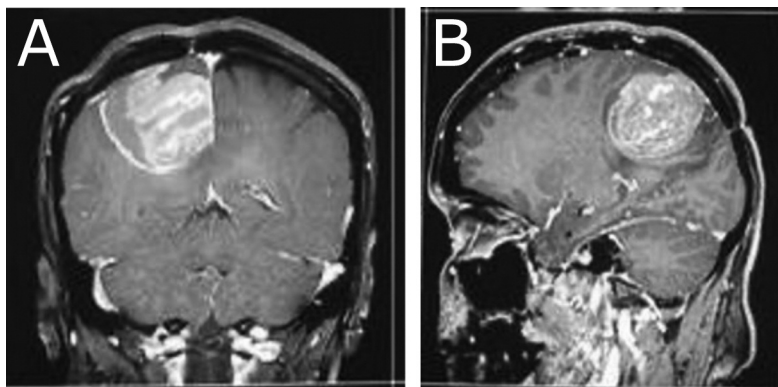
Coronal (A) and sagittal (B) view of a contrast MRI of the patient's brain showing a large intra axial lesion, with heterogeneous enhancement on contrast, causing mass effect and midline shift on the surrounding brain.
